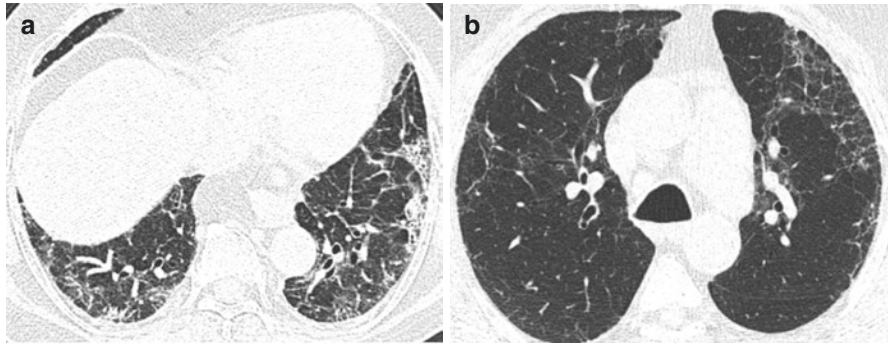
(a, b) HRCT images of two patients with COVID-19 pneumonia showing predominantly subpleural areas of fibrotic-like changes
